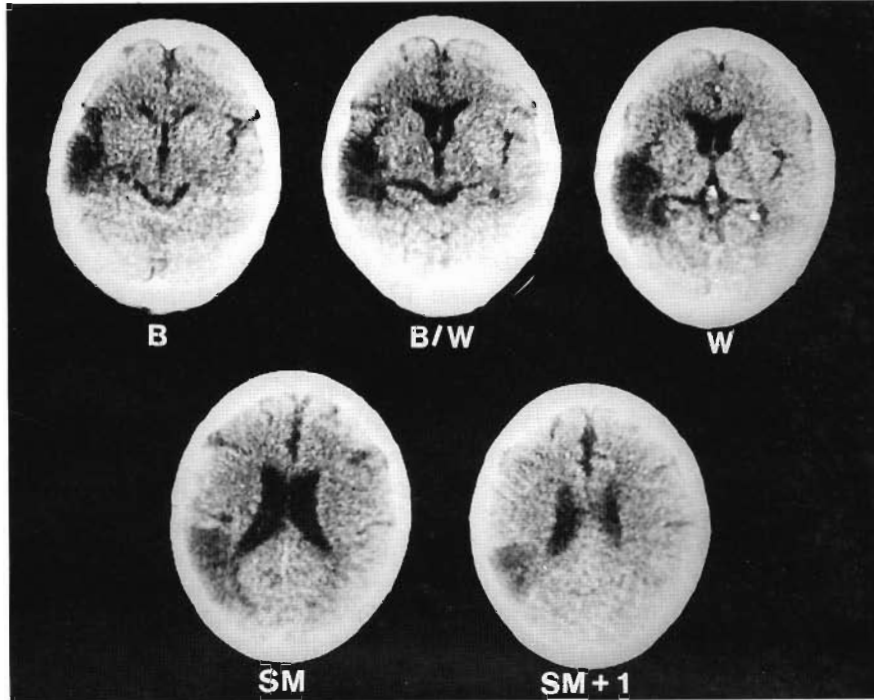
CT scan performed 24 MPO in a patient with mild Wernicke's aphasia who had good recovery (0.9 BDAE auditory comprehension Z score) at T2 testing (7 MPO). Lesion was present only in the posterior half of Wernicke's area on slice W (extent-of-lesion rating, 4.5). There was an additional parietal lobe lesion in the anterior and posterior supramarginal gyrus areas, surface and deep. (Reprinted from Naeser et al., 1987.)
